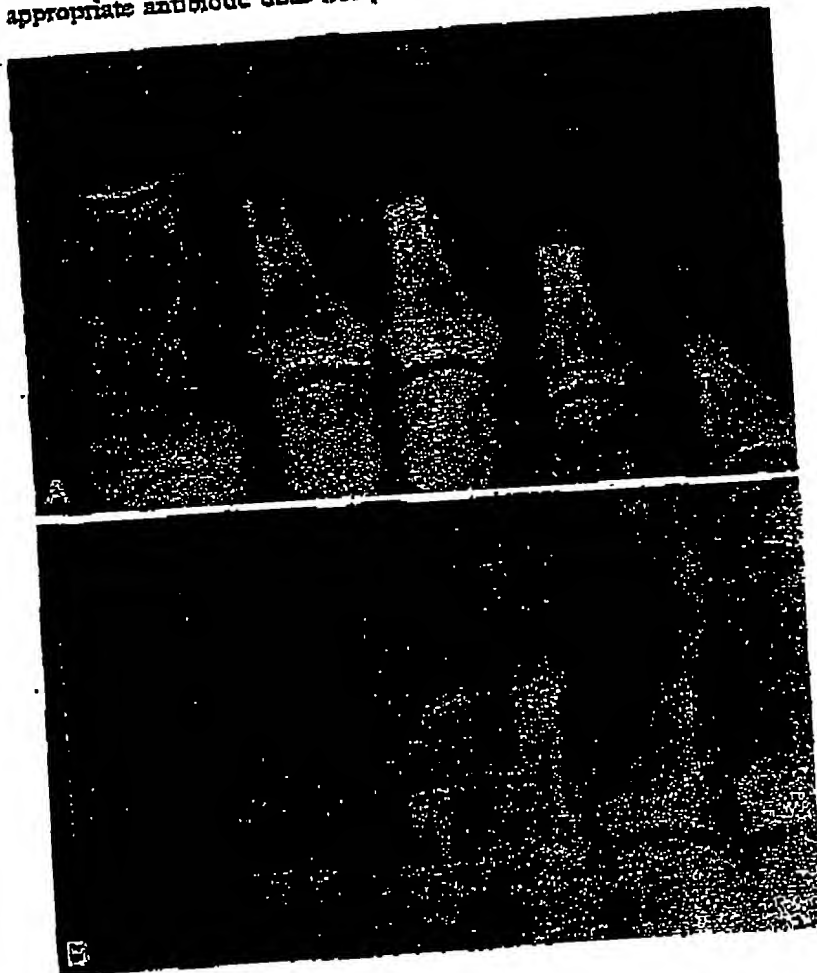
A. X-ray of implants in four lesser toes. Note flat position of the implants in the second, third, and fourth toes; B, note flat or horizontal position of implant in the fourth toe.
